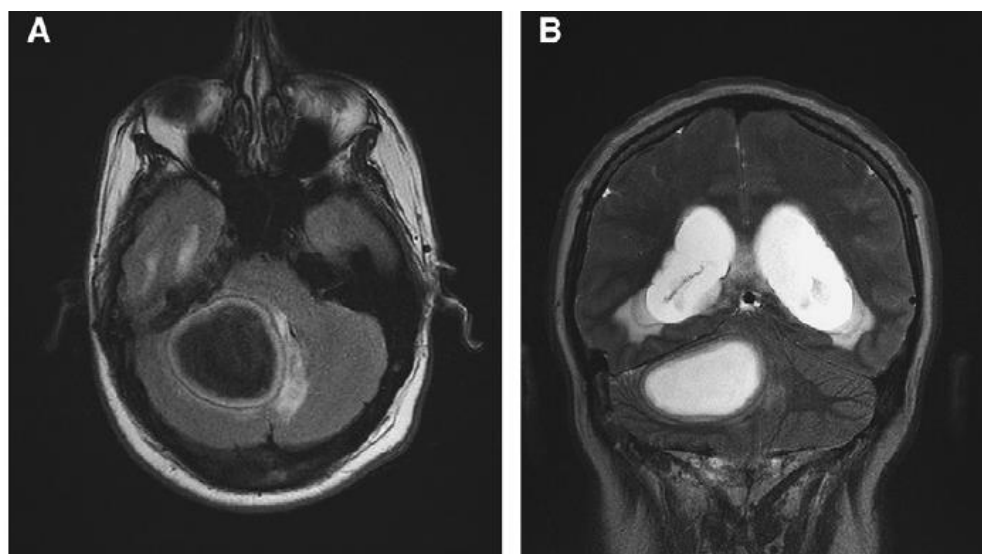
An axial T1-weighted MRI (A) and a coronal T2-weighted MRI (B) demonstrating a large right cerebellar brain abscess with resulting hydrocephalus.
